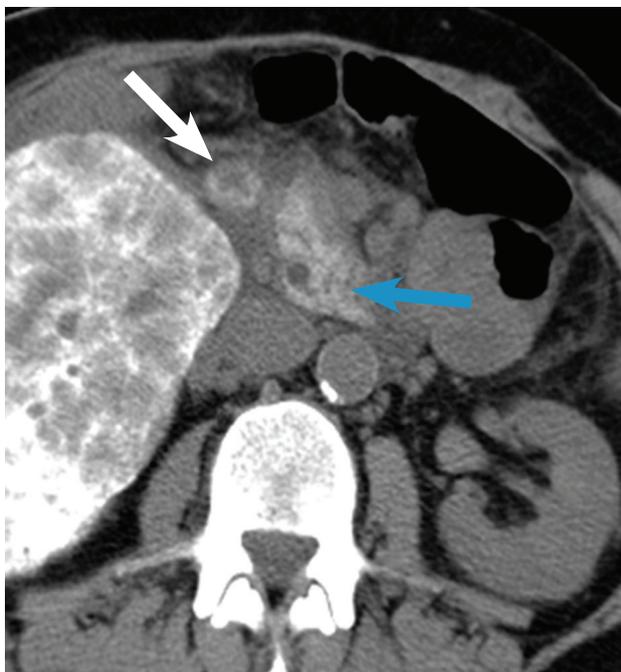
Axial non-contrast CT image obtained without oral or intravenous contrast shows non-target embolization of the head of the pancreas (blue arrow) and duodenum (white arrow), as well as appropriate deposition of the ethiodized oil in the right lobe of the liver after lobar TACE
